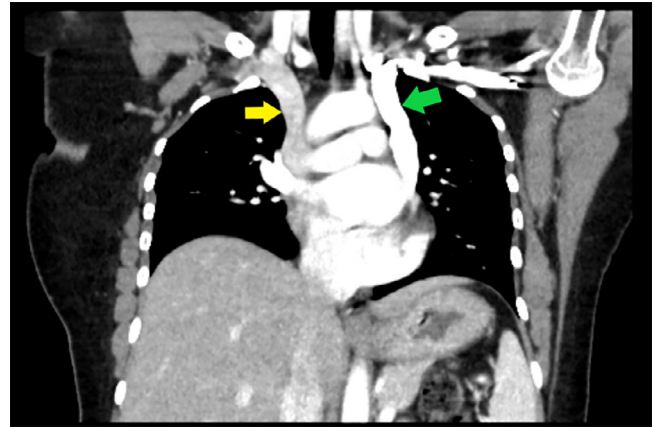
Coronal view, CT angiogram of the thorax, demonstrating both the right SVC (yellow arrow) and PLSVC (green arrow) inserting into the right atrium.
